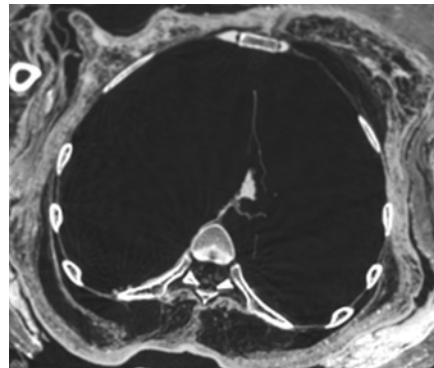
CT scan of the chest of ROM 910.5.3, showing remnants of the great vessels in the incised pericardium.
